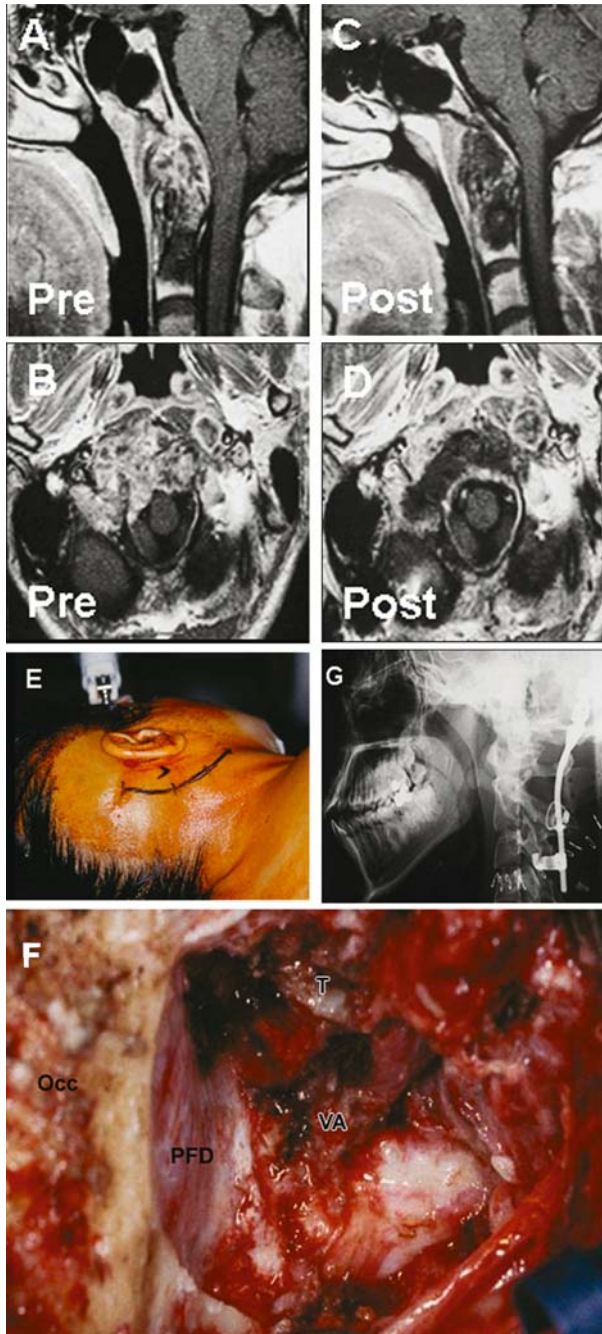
Extreme lateral transcondylar approach for the removal of an inferior clival chordoma with significant lateral extension. A and B represent sagittal and axial preoperative T1w contrast enhanced MRI's with involvement of the craniovertebral junction. C and D are the corresponding postsurgical images. Through a retroauricular incision the craniovertebral junction is exposed (E). A demonstration of the surgical field is given in F. Extensive condylar resection necessitated a fusion procedure (G). Occ occipital bone, PFD Posterior fossa dura, T tumor, LC VA vertebral artery
